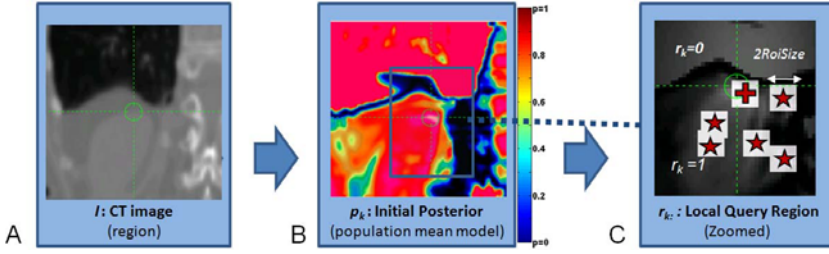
Define a Local Query Region r_k . Example for the top of right kidney. A - CT image, B - posterior from the initial model, C - local query region r_k (red stars are the local modes of the initial model posterior p_k , cross is the mode of the spatial prior p_k^{SC}). Images show a 16x16x16 cm test image region centered at the ground-truth. For clarity, only coronal slice of the 3D volume is displayed.
